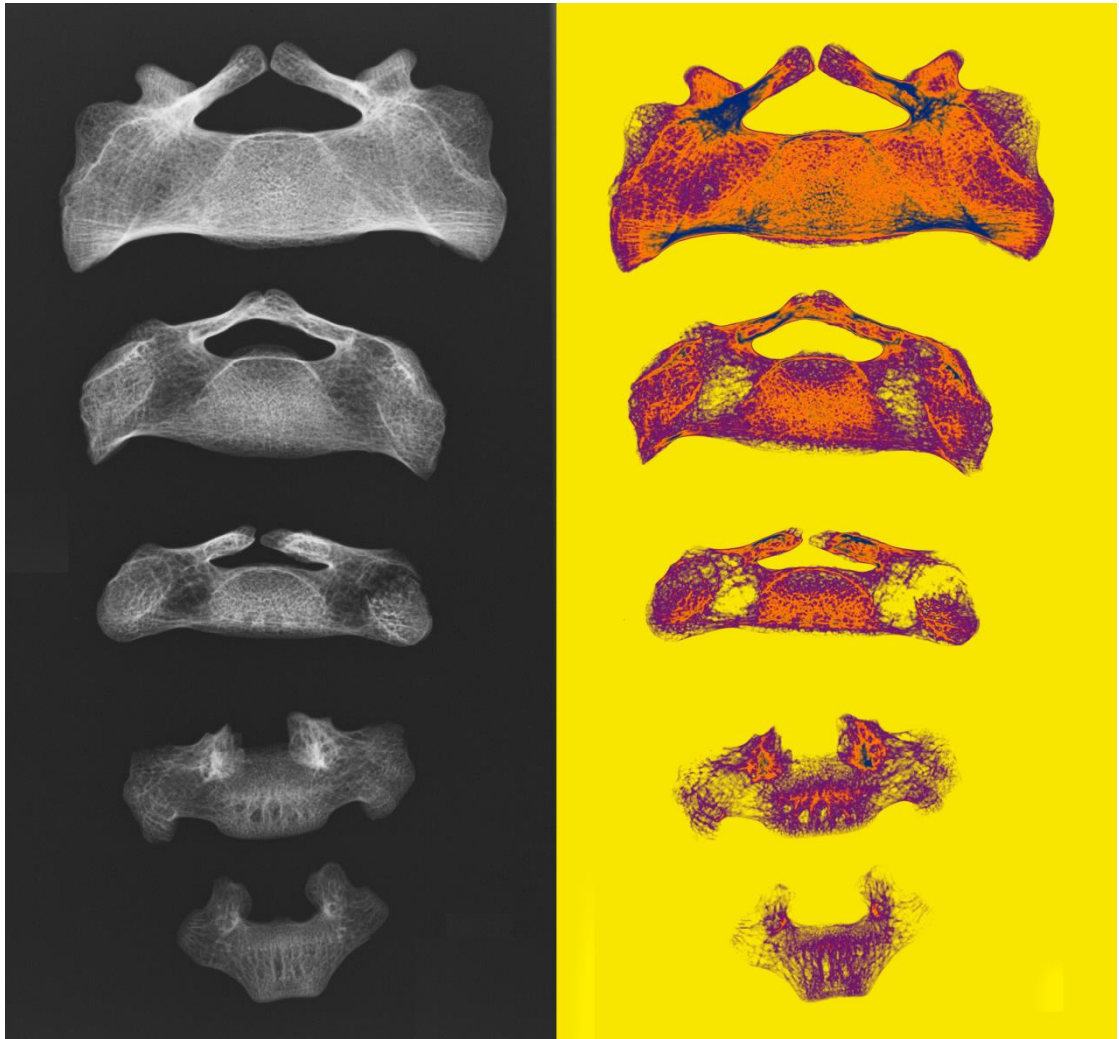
A 5-8 years sacrum in (a) plain radiographic image and (b) Adobe Photoshop's transformed image into four gradient colour mapping.
